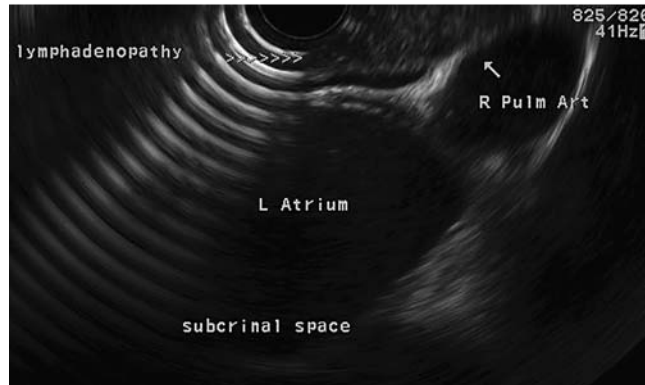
Endoscopic ultrasound (EUS) revealing lymphadenopathy (arrows).
